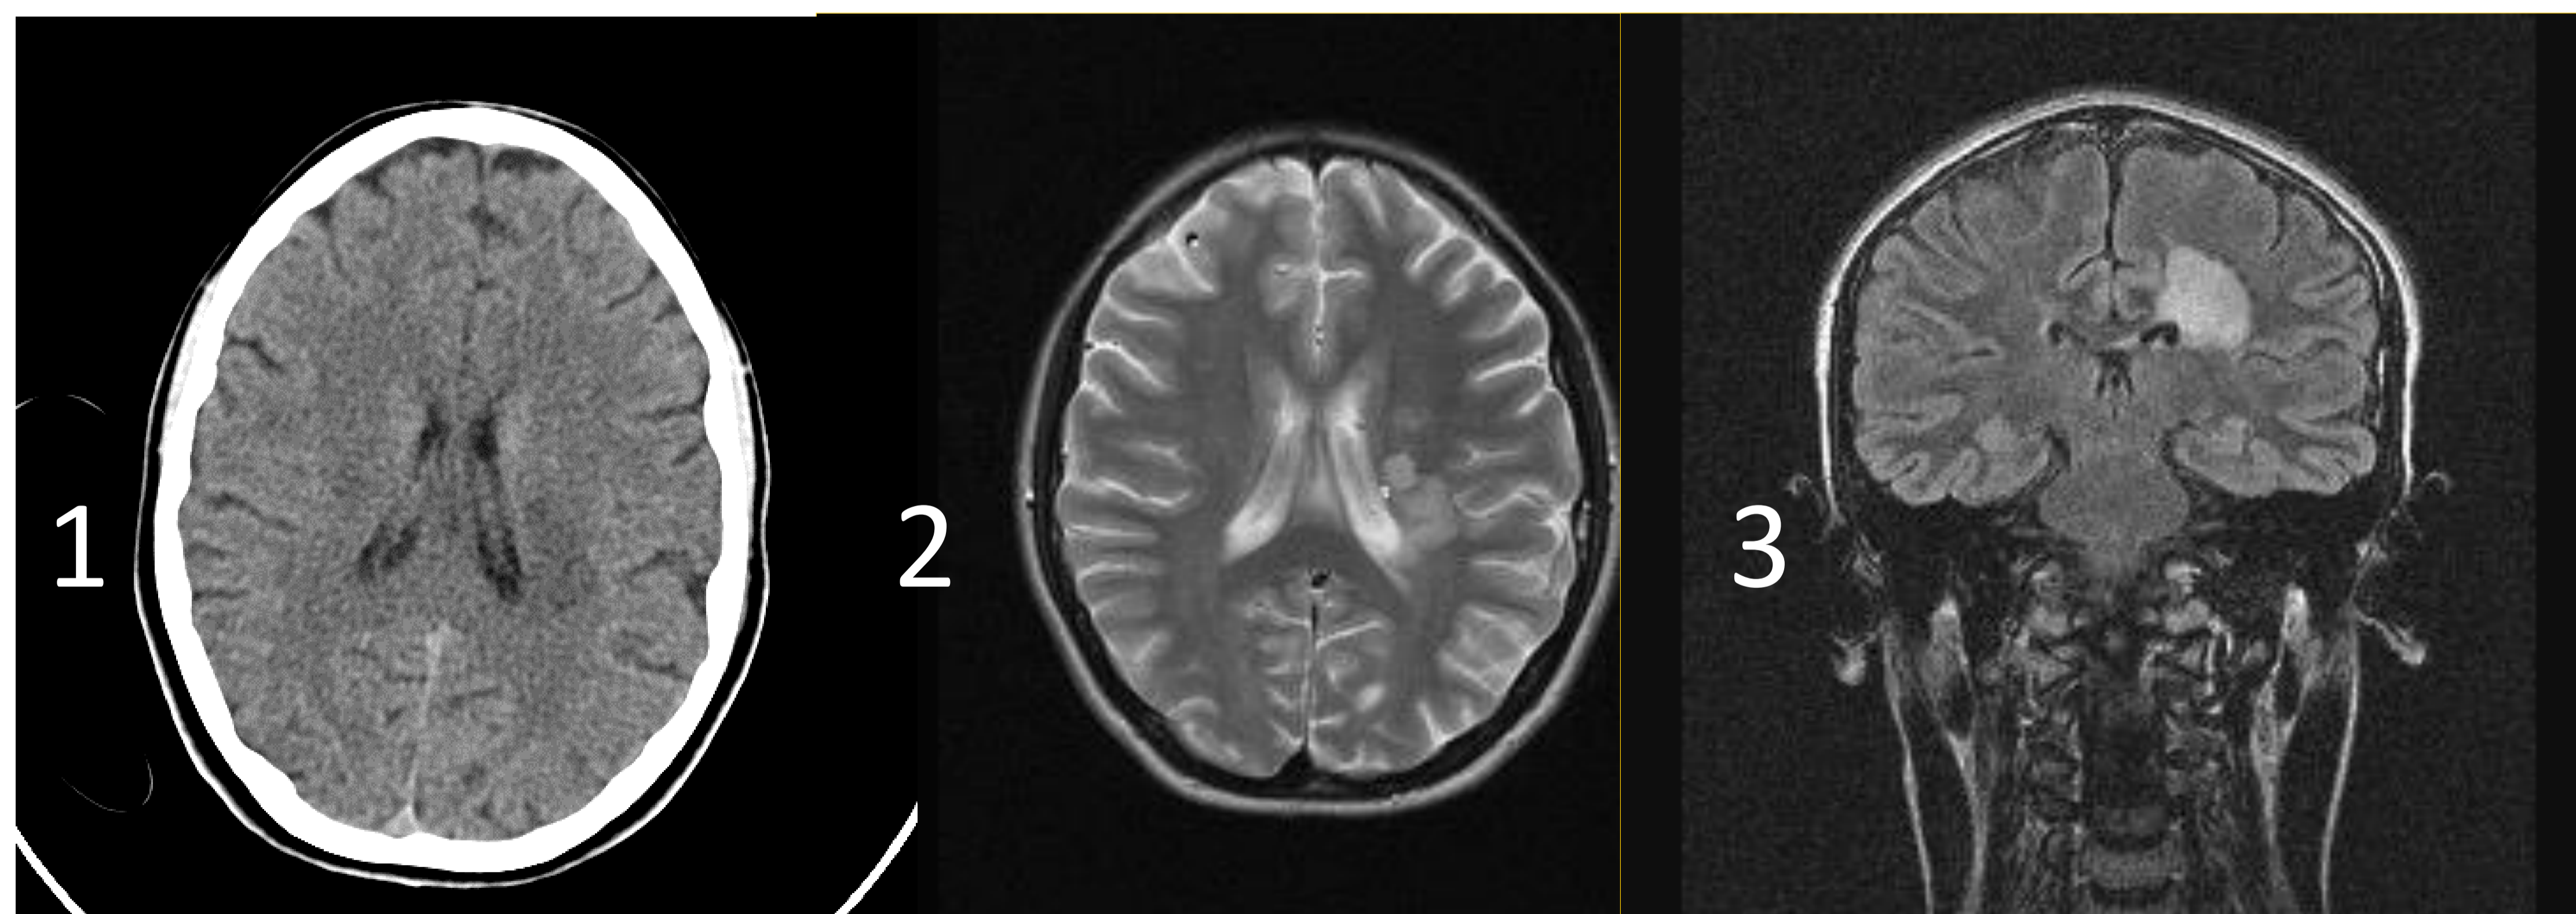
Brain CT revealed a large left periventricular lesion, inhomogeneous and irregular (11); MRI showed the same lesion (3,3/2cm) with enhancement.
